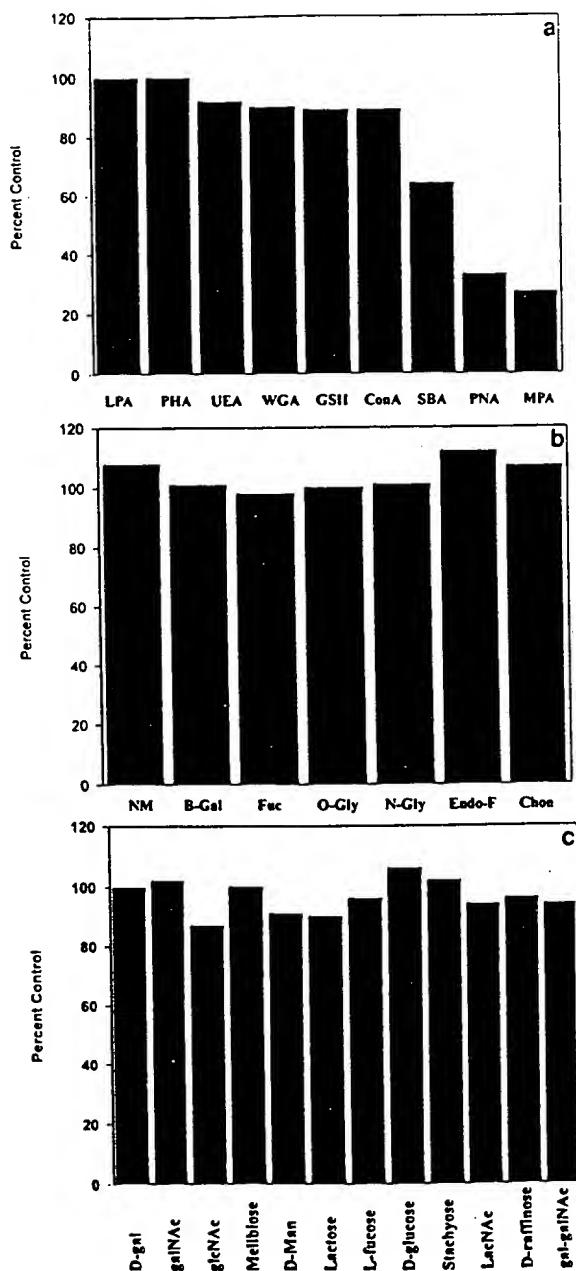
Carbohydrate analysis of the PSMA epitope. A) Competitive lectin-binding experiments showing inhibition with SBA, PNA, and MPA lectins. The carbohydrate specificities for the lectins are as follows: LPA (NeuNAc, D-galNAc, and D-GlcNAc), PHA (oligosaccharides), UEA (α -L-fuc), WGA (D-glcNAc, NeuNAc), GSII (D-glcNAc), ConA (α -D-man, α -D-glc), SBA (α -D-galNAc, D-gal), PNA (D-gal- β (1-3)-D-galNAc), and MPA (α -D-gal). B) Digestion of PSMA from LNCaP membrane extracts with neuraminidase (NM), β -galactosidase (B-Gal), fucosidase (Fuc), O-glycanase (O-Gly), N-glycanase (N-Gly), Endo F, and chondroitinase ABC (Chon). C) Competitive blocking with specific carbohydrates and amino-sugars, demonstrating the inability to block MAb 7E11-C5.3.
